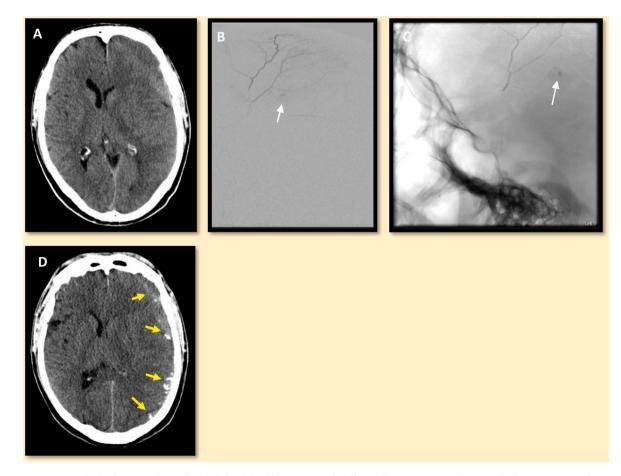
A. Non-contrast CT brain demonstrating a chronic left subdural hematoma with different densities segregated into multiple compartments by membranes. B. Microinjection of contrast into the anterior division of the left MMA. White arrow points to the enhancement of the hematoma membrane. Post-embolization unsubtracted lateral view of the skull demonstrating n-BCA cast within the hematoma membrane. Post-procedure non-contrast CT scan showing n-BCA within the membranes of the subdural hematoma (yellow arrows).
